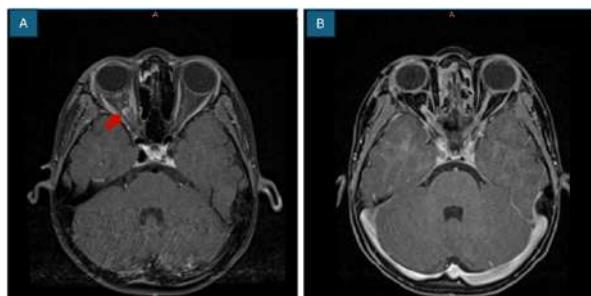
Repeat MRI with gadolinium at (A) 6 months and (B) 1 year after excision of optic nerve glioma. There was resolution of proptosis and a small foci of enhancement seen at tip of right optic nerve (arrow) which represented postoperative granulation changes. Stable imaging findings were noted one year after surgery.
